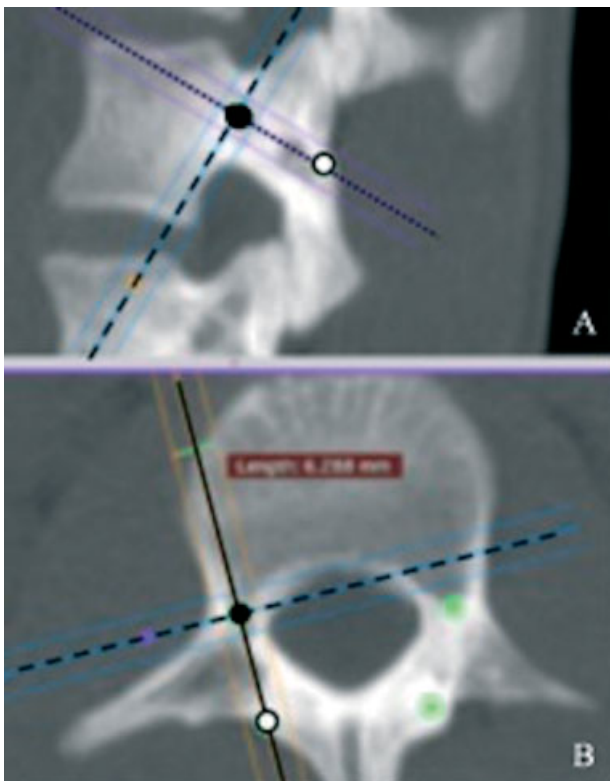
Sagittal (A), and axial (B) computed tomography images showing the calculation of the screw diameter.
